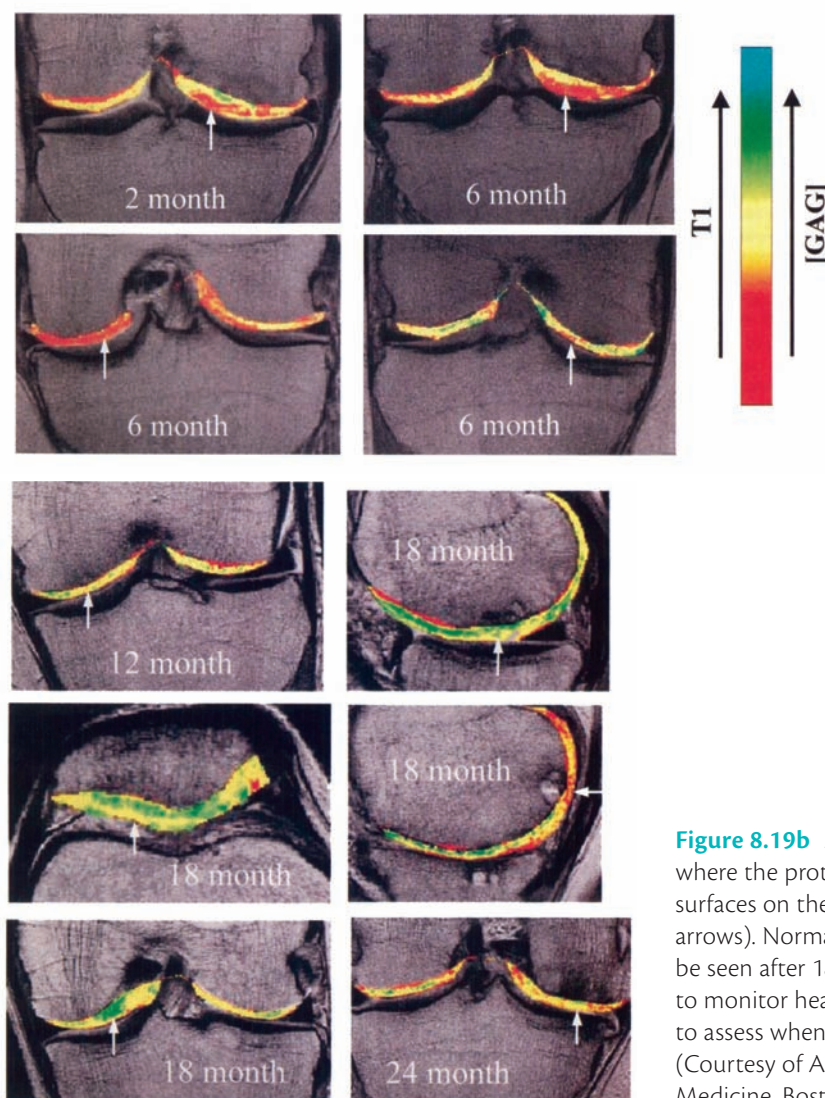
Evaluation of the proteoglycan content after an autologous chondrocyte implantation (ACI). Contrast is injected intravenously. This contrast is searching for negatively-loaded proteoglycans in the joint cartilage (dGEMRIC). After the loading with contrast a magnetic resonance imaging (MRI) examination is carried out. The concentration is read by the scale on the right, where red represents low content and blue high content of proteoglycans. a: an MRI examination 2 months after the ACI; b–d: MRI examination after 6 months. It can be read that the concentration of proteoglycans is low in the joint surfaces on the femur as well as in the transplanted area (see arrow at 2 and 6 months).
